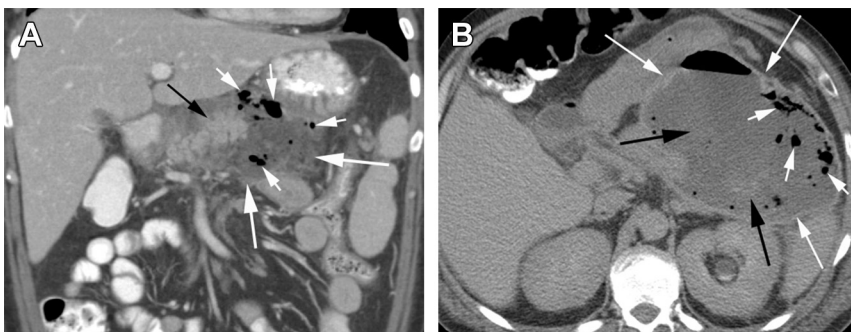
Necrotizing pancreatitis with infected ANC (A) and infected WON (B). (A) This 20-year-old woman developed fever and sepsis and the CT demonstrates multiple air bubbles (short white arrows) in a fluid collection surrounding the edematous pancreas (black arrow), which represents the infected ANC. There is no evidence of a capsule but the collection is heterogeneous. (B) This 55-year-old man had been in the hospital for 6 weeks when his clinical picture deteriorated and a CT demonstrated multiple air bubbles (short white arrows) and an air-fluid level within an encapsulated fluid collection (long white arrows) that involved the pancreas and peripancreatic tissues. Also areas of increased attenuation (black arrows) are present within the WON.
